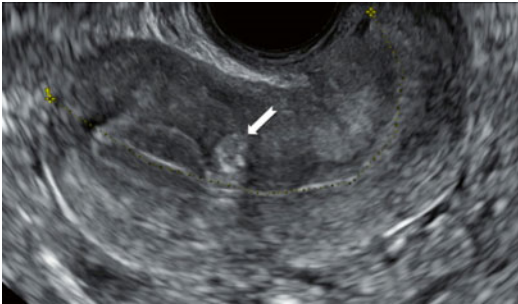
Ultrasound image of a uterus with a hyperechoic buds (*white arrows*) in the myometrium beneath the endometrium
